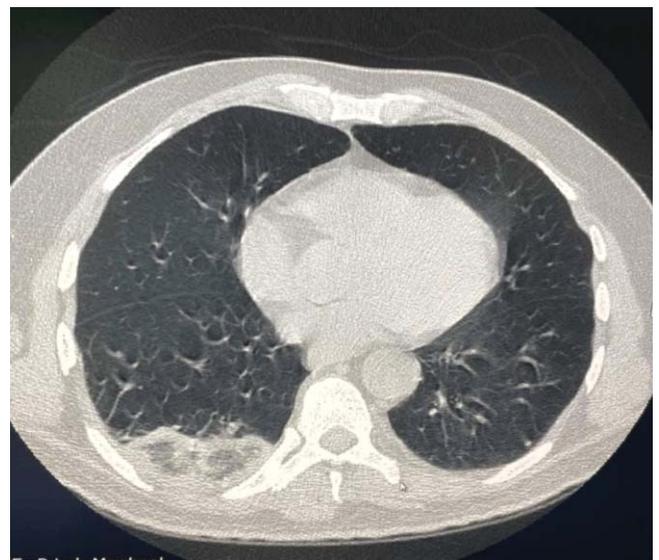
Axial high-resolution computed tomography (HRCT) of a patient with coronavirus disease-2019 (COVID-19) pneumonia demonstrating reverse halo sign: internal ground glass opacity (GGO) surrounded by a thick rim of consolidation in the posterior basal segment of the right lower lobe.
